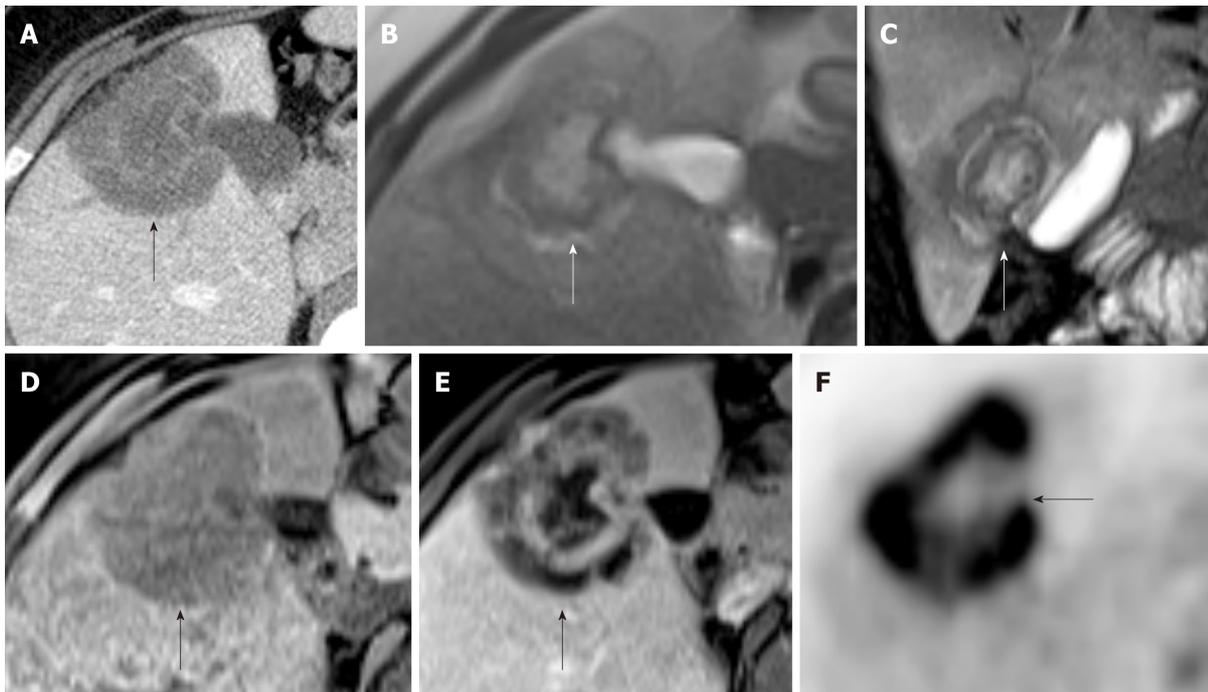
Imaging of hepatic hemangioepithelioma. A: Axial contrast enhanced CT image; B: Axial T2 weighted images; C: coronal T2 weighted images; D: Axial pre contrast T1 Weighted Image; E: Axial post contrast T1 Weighted Image MRI Images; and F: Axial ^{18}F -labeled fluoro-2-deoxyglucose positron emission tomography/computed tomography attenuation corrected image show a hepatic hemangioepithelioma nodule (arrow) with fluoro-2-deoxyglucose uptake.
